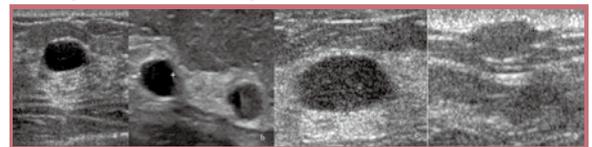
a, typical sonographic appearance of a simple cyst with well-defined margin, anechoic content and through sound transmission. b, cysts with fluid-debris levels. c, low level echogenic cyst content due to crystalline cholesterol. d, sebaceous cyst within the skin, abutting subcutaneous fat.
